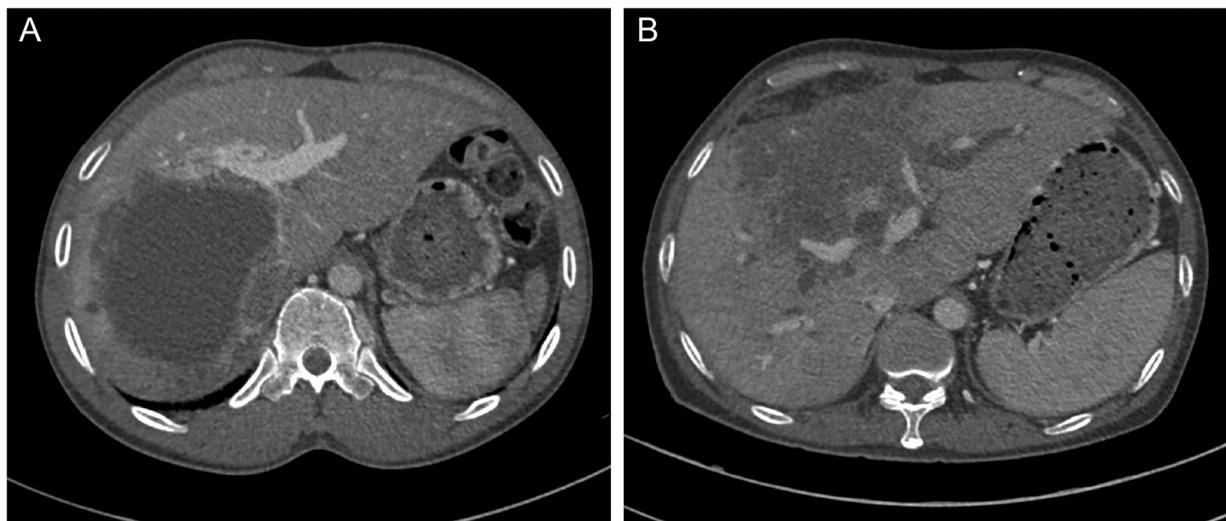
Preoperative assessment of operability. (A) CT scan of a patient underwent *ex vivo* liver resection and autotransplantation revealed a massive lesion invading porta hepatis and retrohepatic vena cava. (B) CT scan of a patient underwent allotransplantation revealed extensive invasion to portal structures, which led to the impracticality of vascular reconstruction.
